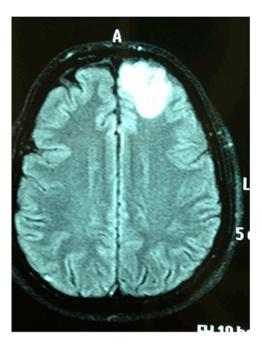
Magnetic resonance imaging of the brain showing an expansive left frontal.
